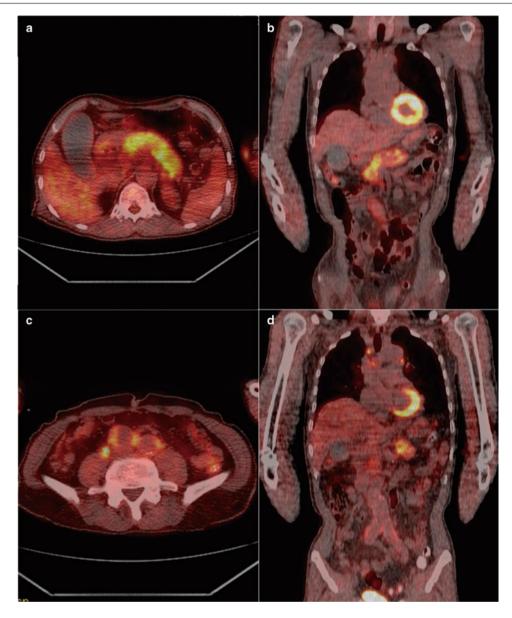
FDG accumulation in the pancreas, abdominal aorta, and large vessels on transaxial (a, c) and coronal (b, d) PET-CT fusion images
